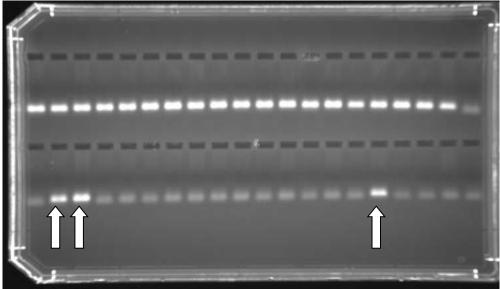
Electrophoregram of polymorphism of the gene CYP2C9 * 2 C430T in patients with ischemic heart disease. Note: The arrows denote heterozygotes along the pathological allele of the CT. The unmarked positions correspond to homozygotes over the normal CC allele.
